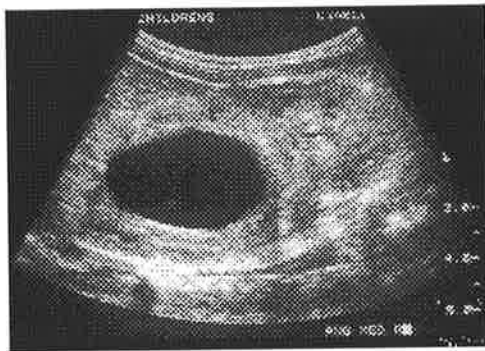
(left): An ultrasound showing dilatation of the upper pole collecting system, out of proportion to the degree of ureteric distension Figure 59 (right): The pre-operative cystogram with reflux into the dilated upper pole ureter which inserts ectopically into the urethra.
